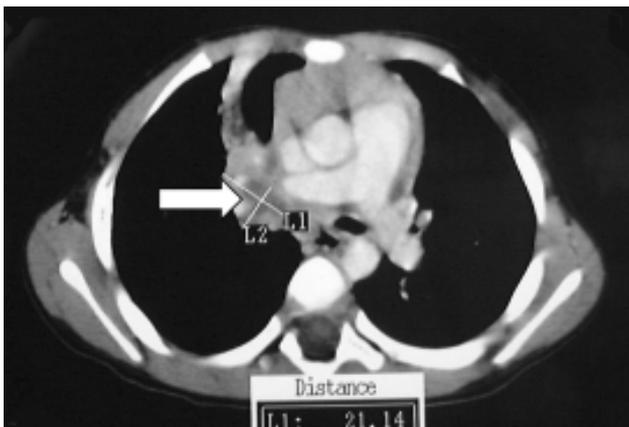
CT scan of thorax with contrast. Multiple enlarged, necrotic mediastinal and right hilar lymph nodes (arrow).
